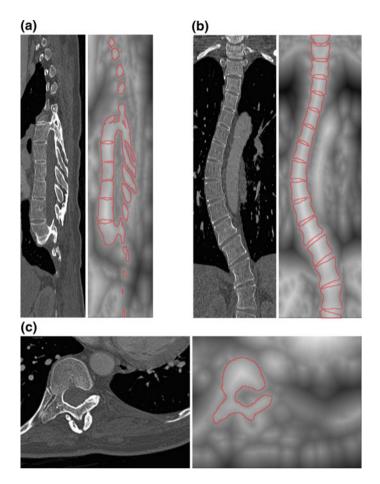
Original image I (*left*) and the corresponding distance transform D_I with superimposed spine boundaries (*right*), displayed for a selected a sagittal, b coronal and c axial cross-section of a 3D CT image of a scoliotic spine. In the distance transform D_I , *brighter elements* represent positive distances, while *darker elements* represent negative distances
